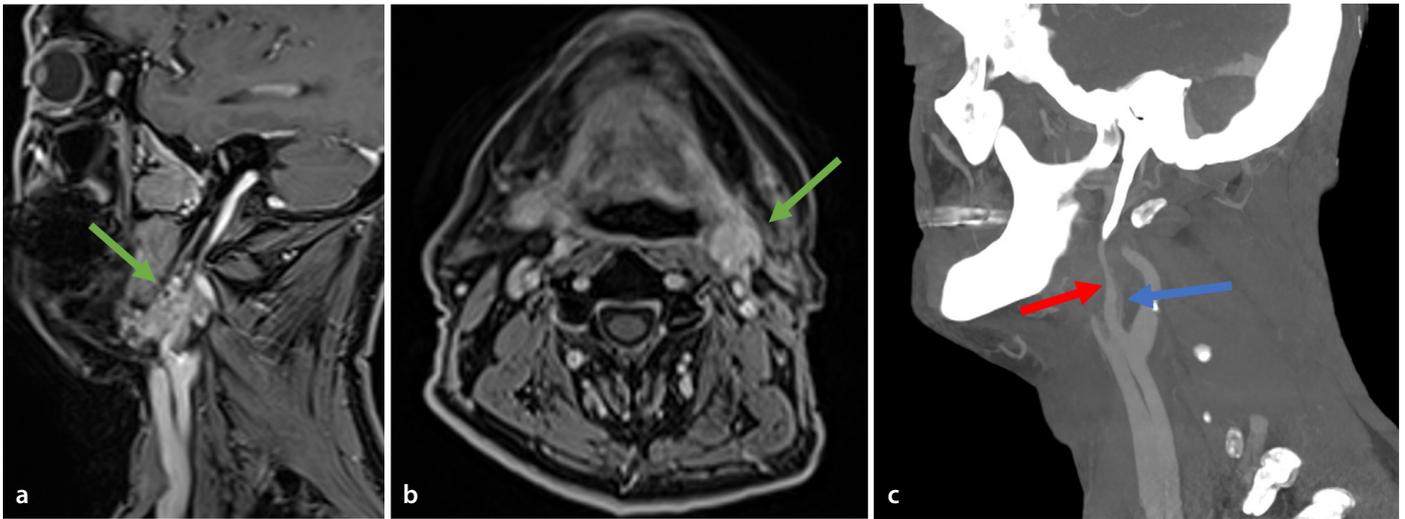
Sagittal (a) and axial (b) contrast-enhanced magnetic resonance imaging confirmed a lymphadenopathy in the retromandibular region (IIa level, approximately 22 × 17 mm; green arrow); computed tomography sagittal image (c) showing left internal jugular vein and external carotid artery involvement (blue and red arrow, respectively).
